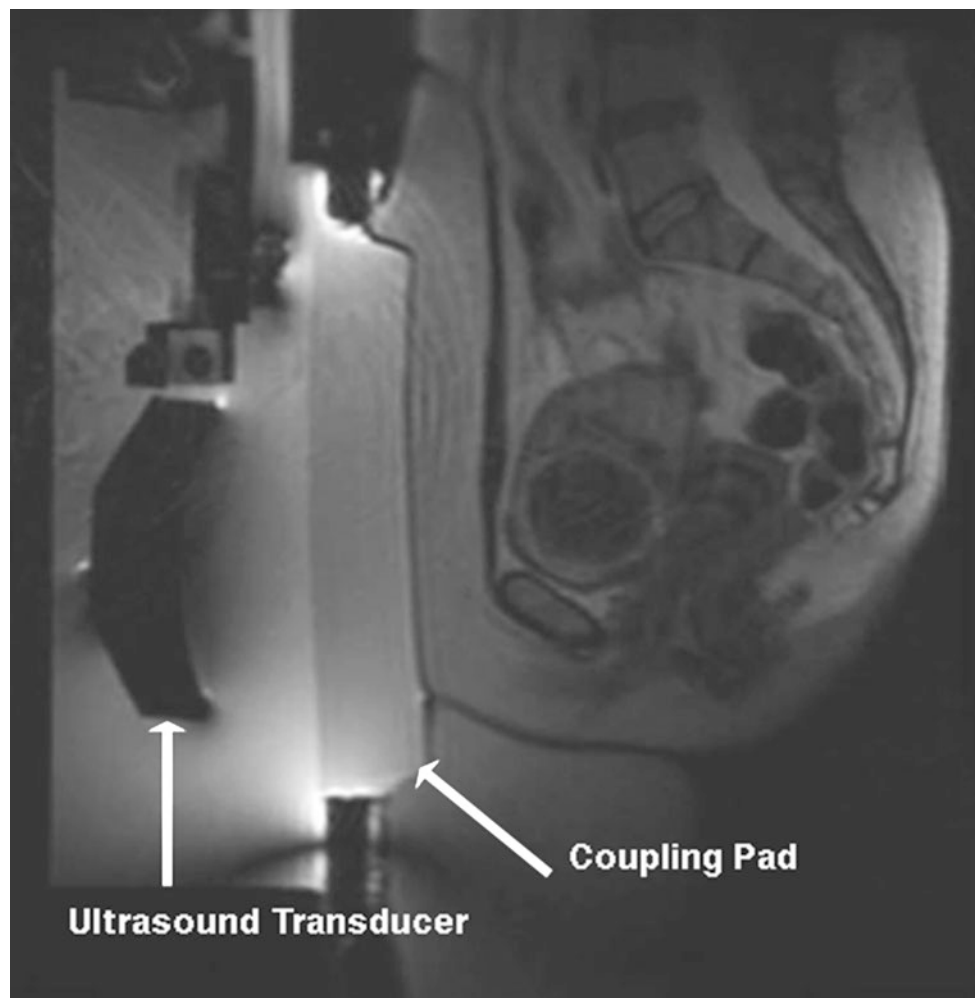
A preliminary scan that demonstrates the ultrasound transducer, and the coupling pad. Ideally, the fibroid should be directly opposite the concave portion of the transducer. This positioning is very good
